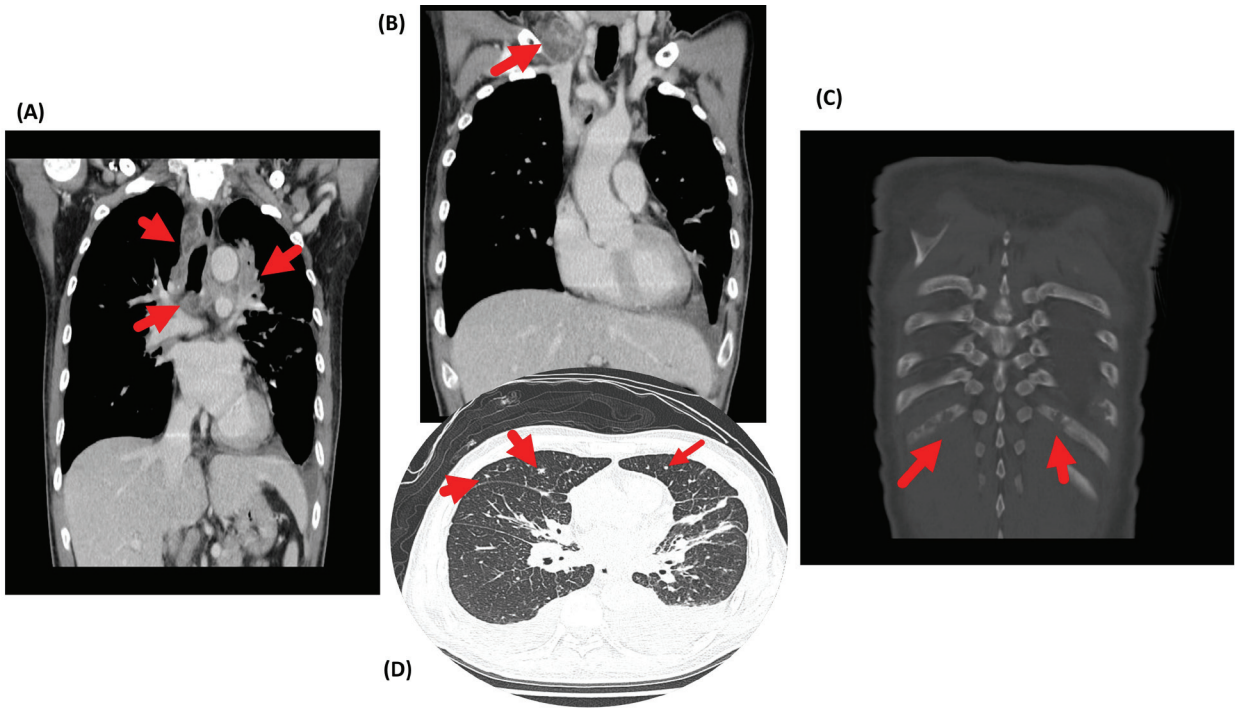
Chest computed tomography with contrast shows (A) infiltrative mass in the medial portion of the left upper lung and multiple necrotic mediastinal lymphadenopathies, (B) right supraclavicular lymphadenopathy, (C) destructive lesions at the bilateral ribs, and (D) multiple nodules of varied sizes in both lungs and bilateral pleural effusion.
